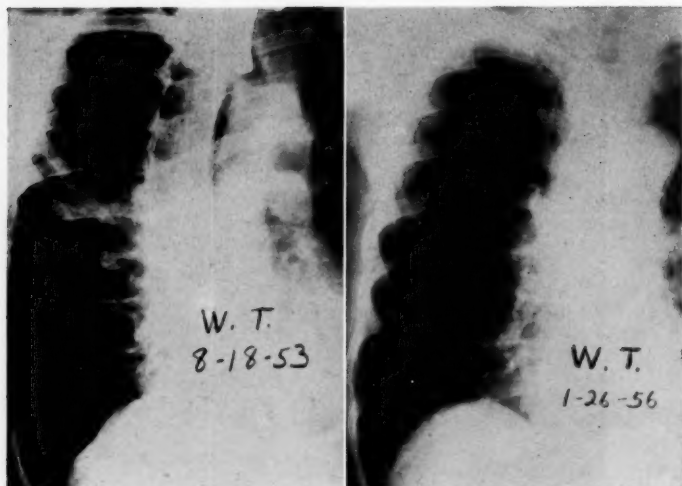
W.T. (Case 5). Small metastasis in right lung base (see arrows) has remained stable or possibly regressed in interval from 8-18-53 to 1-26-56. Note tracheostomy tube has been removed and trachea has adequate lumen, but S-shaped curve in x-ray taken 1-26-56.
